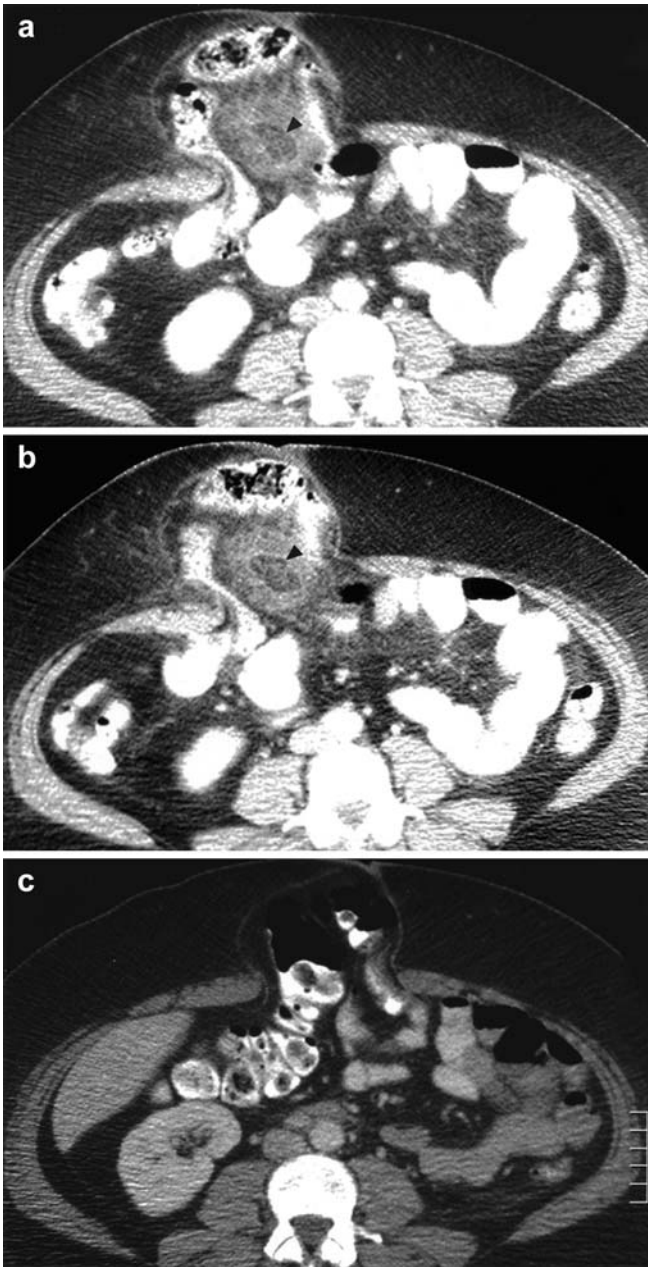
A 46-year-old with acute epiploic appendagitis. a, b Contrast-enhanced CT shows a fat density lesion (*arrowheads*) with surrounding inflammation located within the anterior abdominal wall hernia sac. c Contrast-enhanced CT performed 9.5 months earlier showed the hernia sac containing transverse colon
